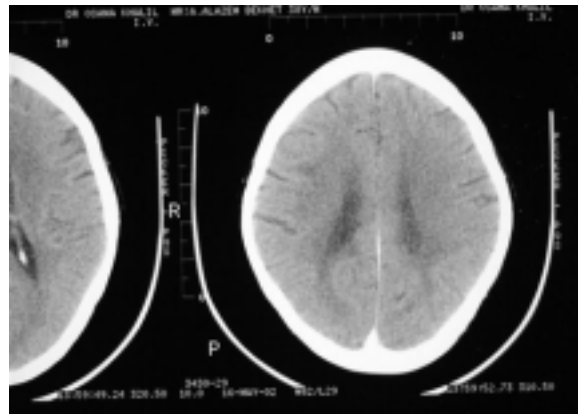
Patient 3, CT scan after treatment.
